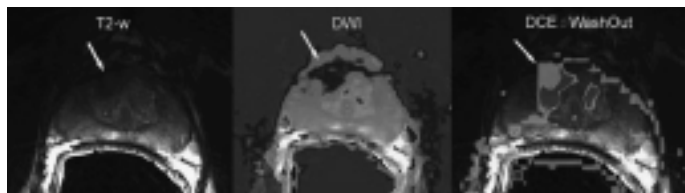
Multi-modality MR images of prostate with TSR
